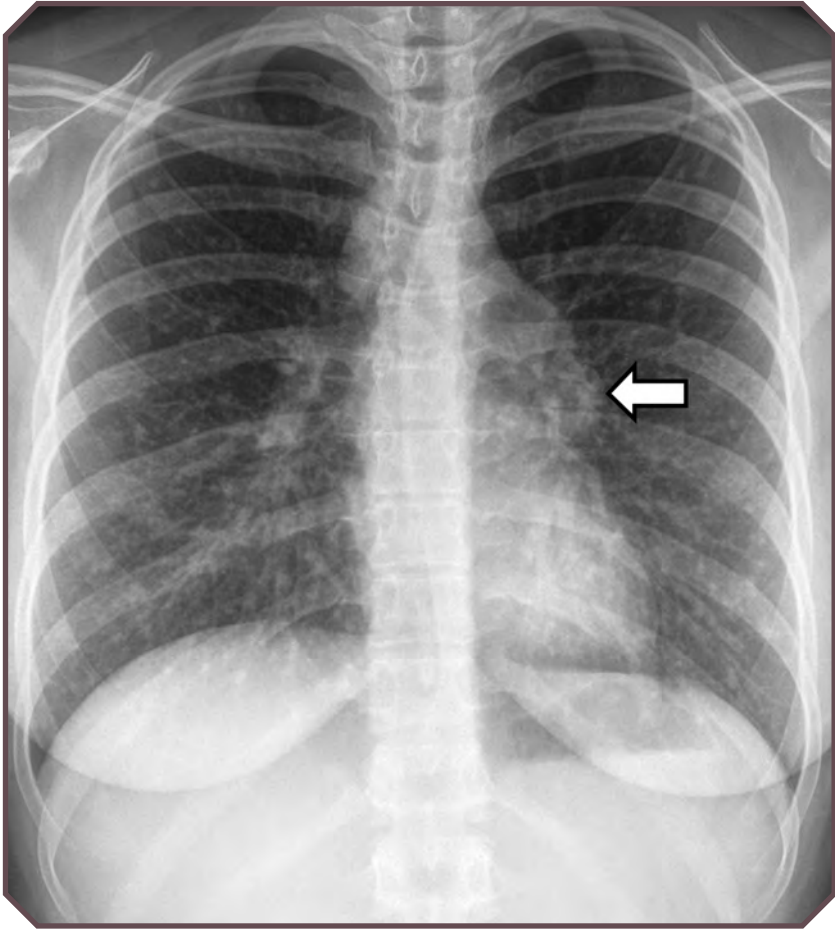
Histoplasma* pneumonia in a 16-year-old girl. Frontal chest radiograph shows diffuse reticulonodular opacities, as well as right paratracheal and left hilar adenopathy (arrow).
